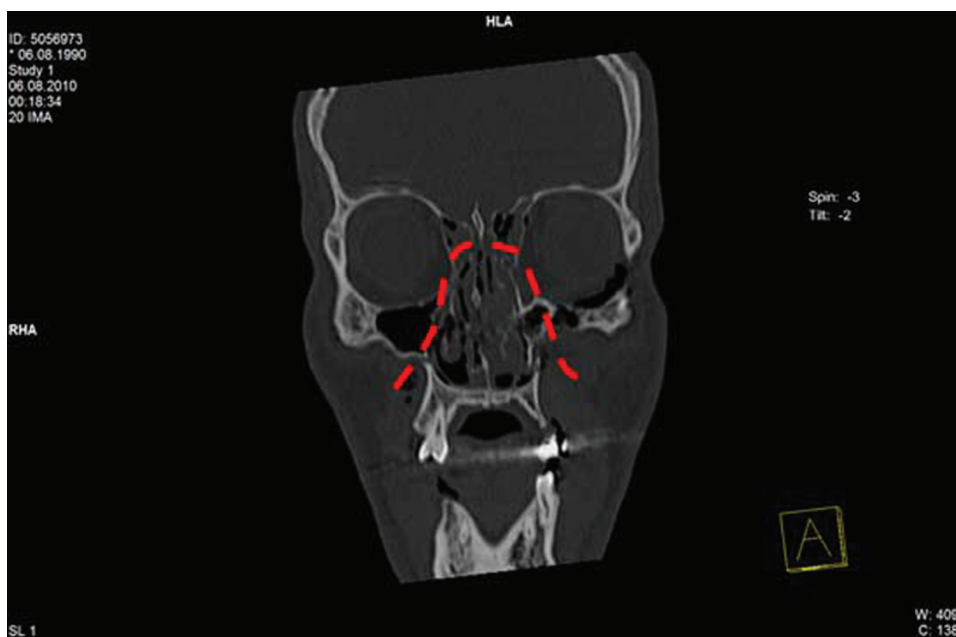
LeFort II fracture shown on a coronal slice of a CT.
